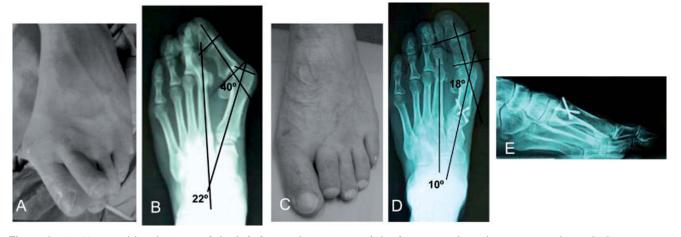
A) 41-year-old male, view of the left foot with pronation of the first toe and overlapping second toe. B) Preoperative x-ray study. C) Surgical technique for Regnauld procedure: proximal osteotomy of the first metatarsal. Final result at 2 years. D) and E) angular corrections; correction of the metatarsophalangeal angle by 22° and of the intermetatarsal angle by 12°. American Orthopaedic Foot and Ankle Society scale: 95 points; excellent subjective evaluation.
